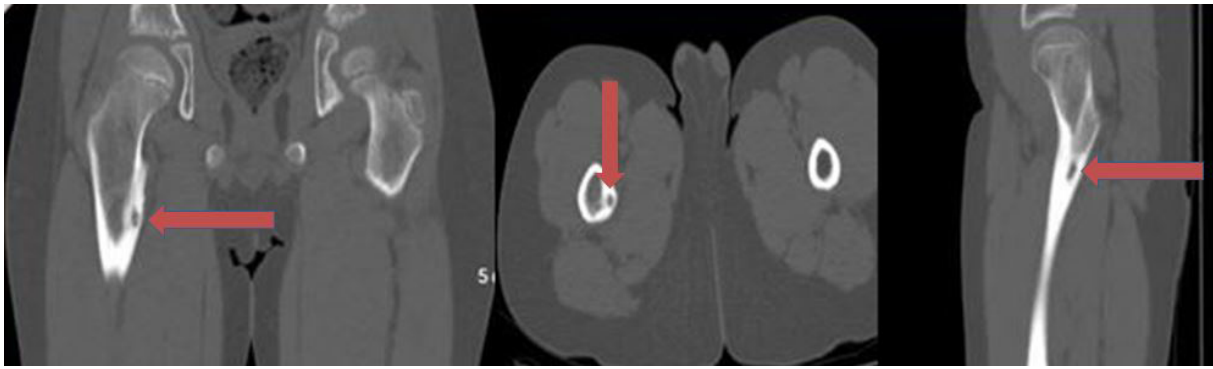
View of the nidus at the level of the right femur trochanter minor detected by computed tomography
